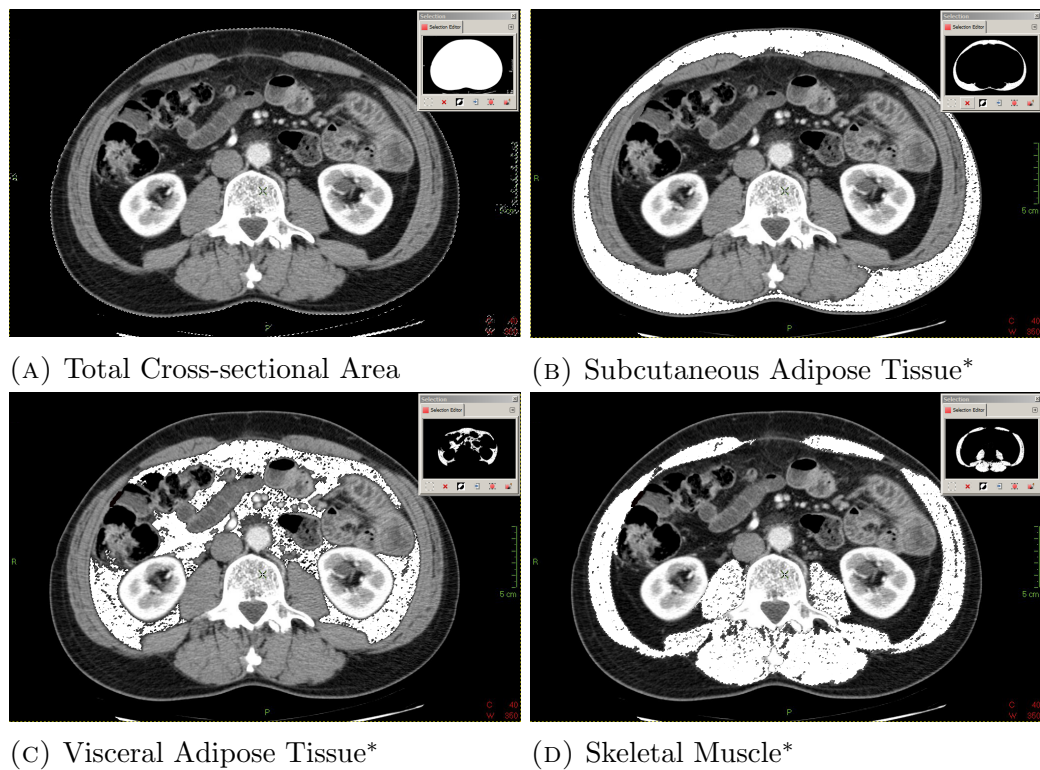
Selection of components of body composition from CT images using GIMP.
